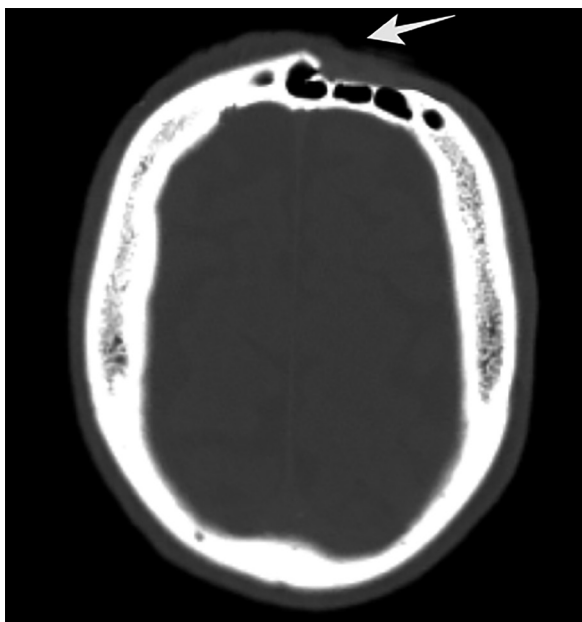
Non-contrast brain computed tomography showed a displaced fracture line on the left anterior aspect of the upper part of the frontal sinus (white arrow).
